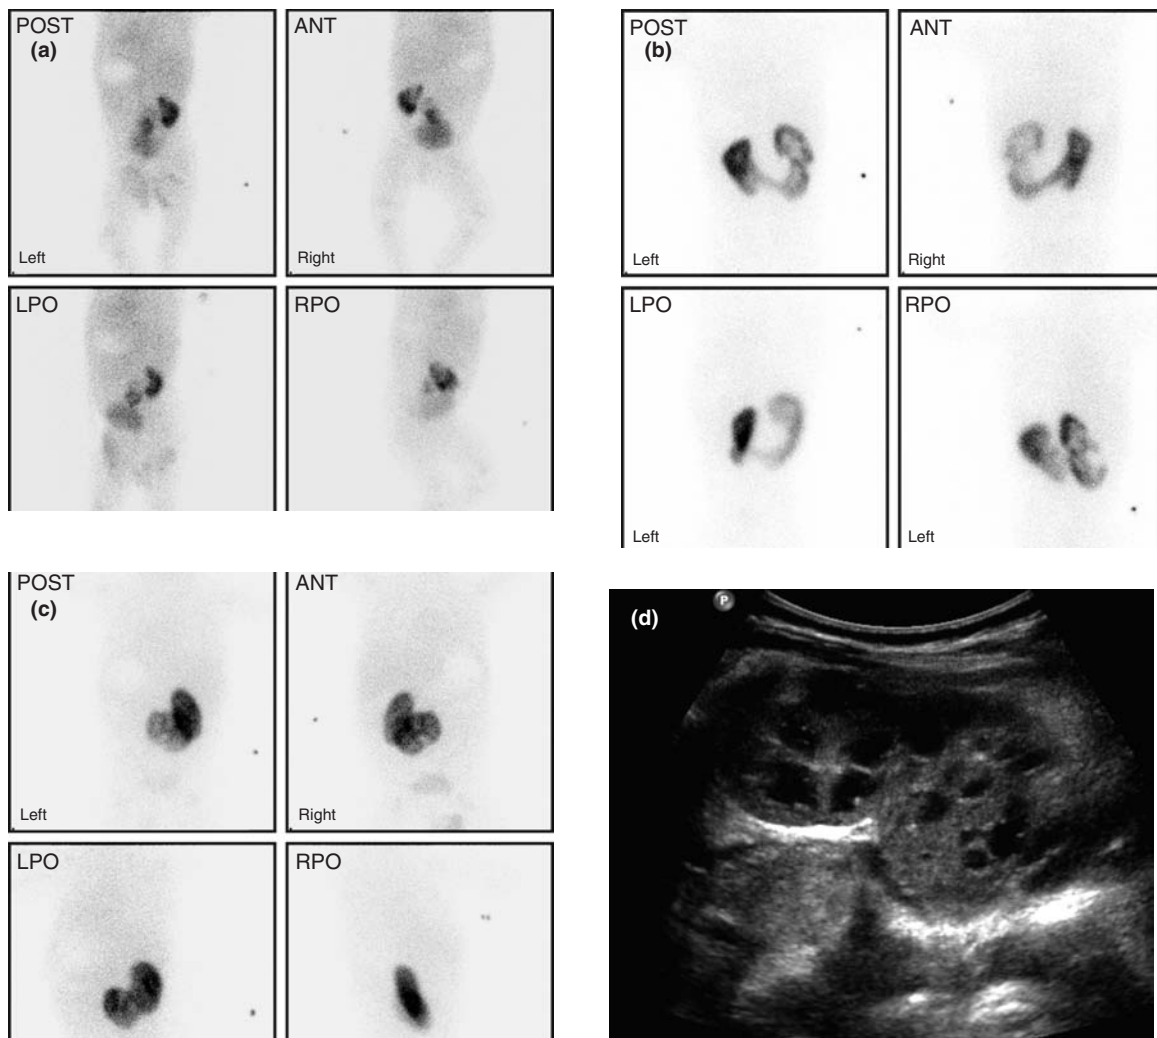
DMSA images of ectopically located renal tissue: (a) ectopic left pelvic kidney; (b) horseshoe kidney with functioning tissue crossing the midline; and (c) crossed fused ectopic kidney with (d) ultrasound demonstrating the two fused moieties in this patient.
